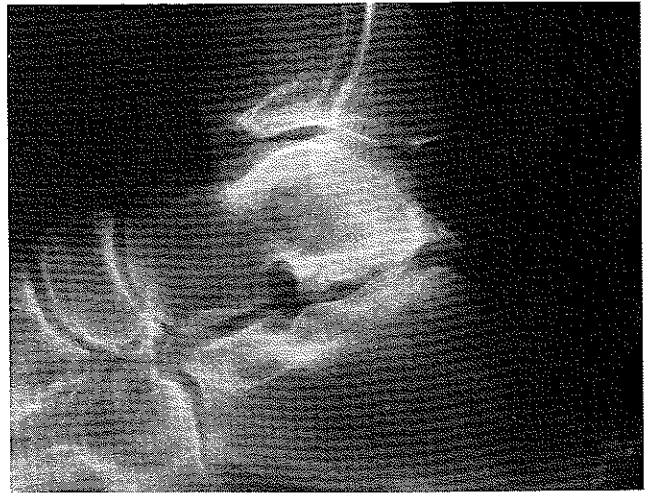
This plain radiograph shows a flattened posterior subtalar joint facet and subchondral sclerosis in a patient with a history of chronic ankle sprains.
